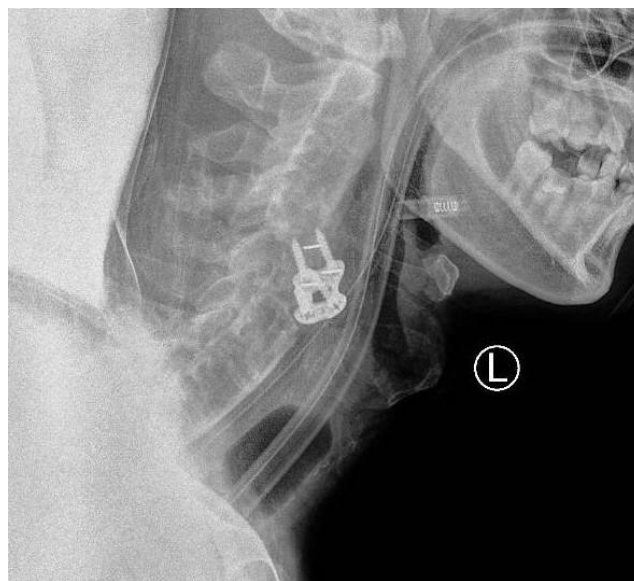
Anterior fixation were observed on preoperative x-rays.
